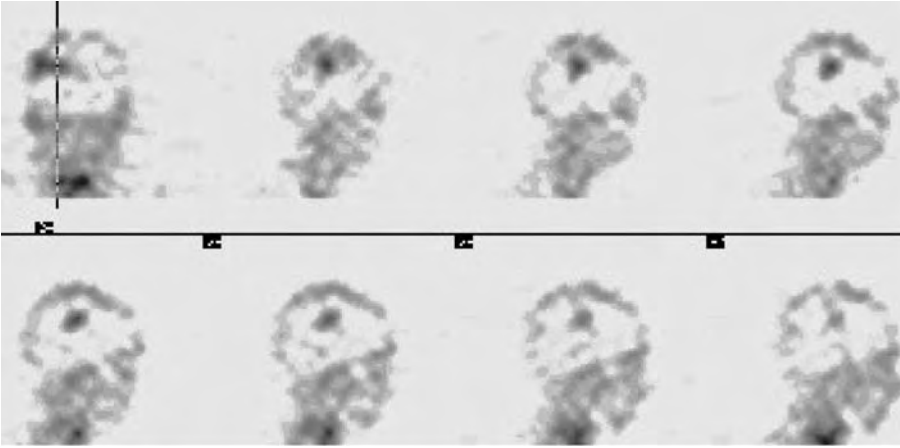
^{99m}Tc -Demotensin scintigraphy in a patient with NSCLC. The SPECT study shows a single metastasis in the brain at 2 h post injection. (Courtesy of Dr. Gabriel, Innsbruck)
